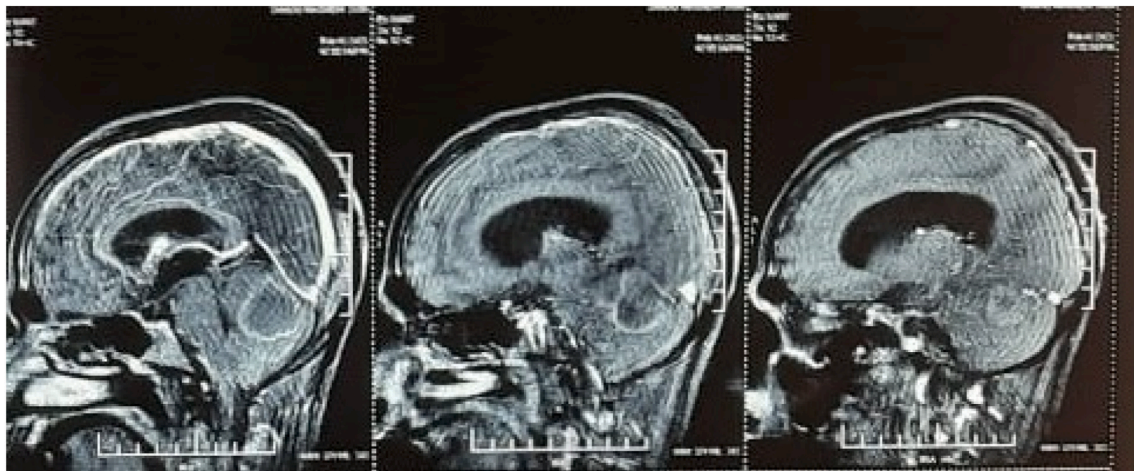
are the magnetic resonance imaging of the brain showing a well-defined lesion in the posterior fossa, on the left side with contrast uptake and ring enhancement of the wall.
